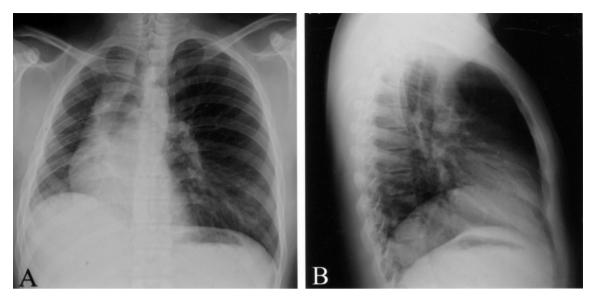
(A) Postero-anterior chest radiograph reveals a small right hemithorax with rightward shifting of the mediastinum. (B) Lateral view reveals an elevated right hemidiaphragm without evidence of lobar collapse.
